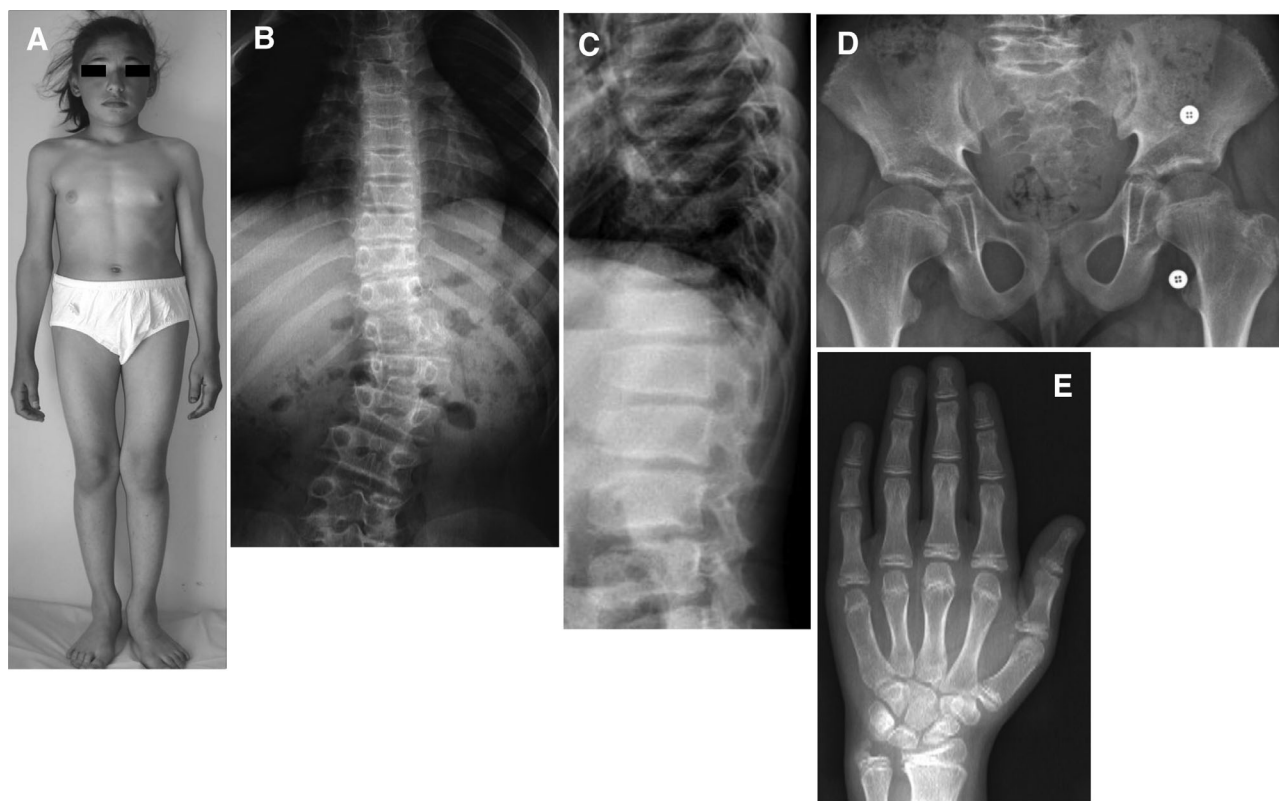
Clinical and radiographic features of brachyolmia caused by *PAPSS2* mutations. A: clinical appearance of P1 (patient 1) at the age of 14 years. Short-trunk short stature with normal facies. The upper extremities are relatively long. B–E: Radiographs. B: Spine A–P (antero–posterior). P5 at the age of 12 years. Mild lumbar scoliosis and overfaced vertebra. C: lateral spine. P2 at the age of 14 years. Mild flattening of vertebral bodies (rectangular vertebra) and irregular end plates. D: Hip A–P. P13 at the age of 9 years. Short femoral neck with longitudinal striation. E: Hand D–V (dorso–ventral). P5 at the age of 12 years. Short metacarpals.
